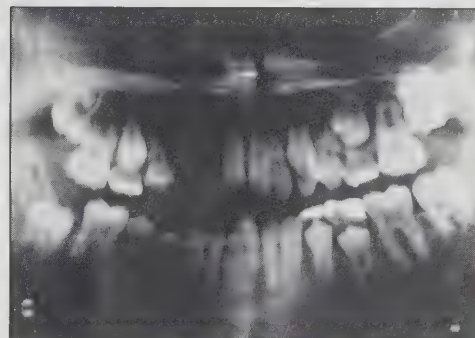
Posttreatment panoramic radiograph. Note the change in position of the lower right first molar following luxation.
